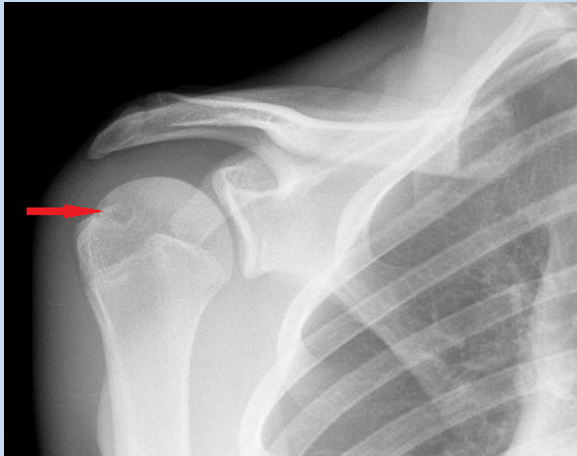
Anteroposterior radiographic view with external rotation showing a greater tuberosity fracture (arrow).
